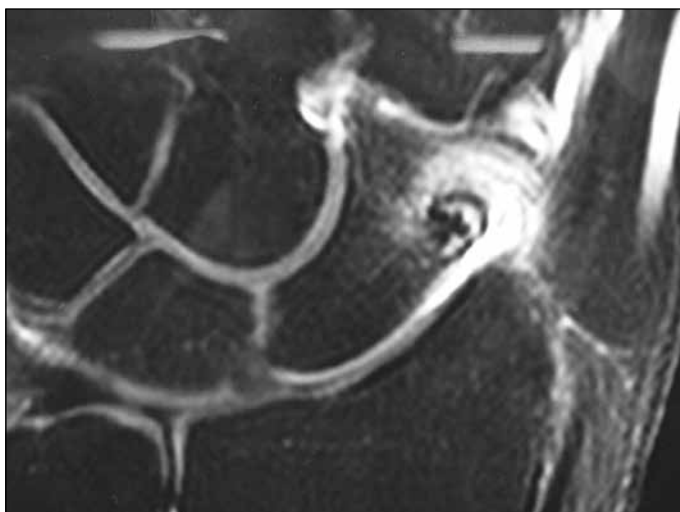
Magnetic resonance imaging demonstrating reactive sclerosis surrounding central radiolucency (niche), thus leading to the diagnostic hypothesis of osteoid osteoma in the scaphoid.
